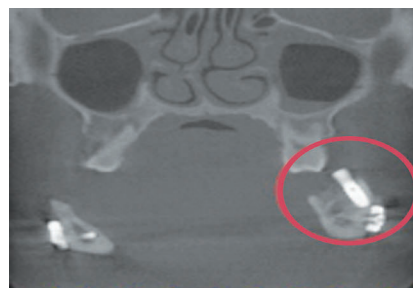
The cone beam CT information showed that no obvious bone resorption was found one year after the final restoration (red circle).
